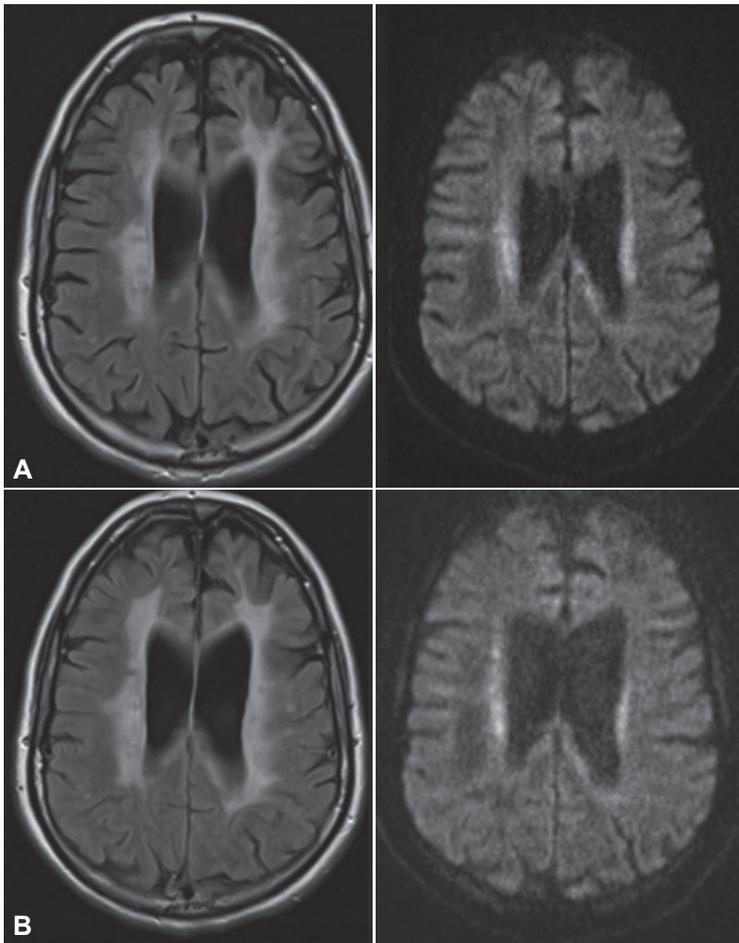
Cerebral MRI at the first visit (A) and nine months later (B). A: Cerebral MRI at the first visit. Confluent hyperintensities in the periventricular and deep white matter (FLAIR, left) with partly restricted diffusion (diffusion-weighted, right). B: Cerebral MRI nine months later: increasing hyperintensities affecting almost the entire white matter (FLAIR, left). FLAIR: fluid-attenuated inversion recovery.
